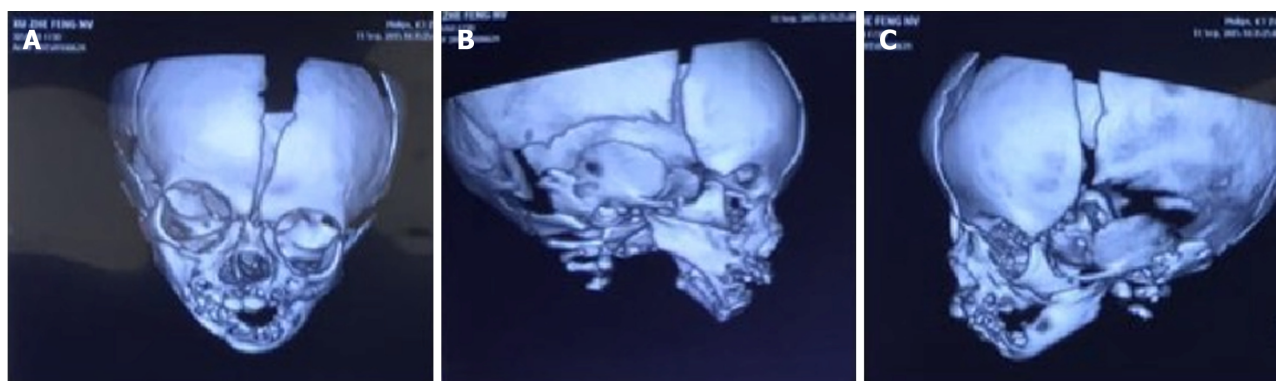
Three-dimensional computed tomography images demonstrating bony fusion of bilateral maxillaries to the mandibles. A: Frontal view; B: Right lateral view; C: Left lateral view.
